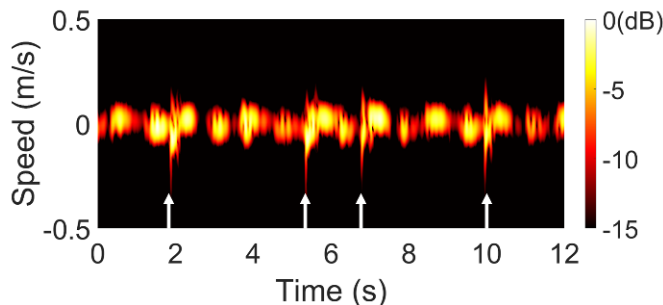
Micro-Doppler signature due to the eyes-blinking during costal breathing. The white arrows indicate the eyes-blinking at 2 s, 6 s, 7 s and 10 s.
